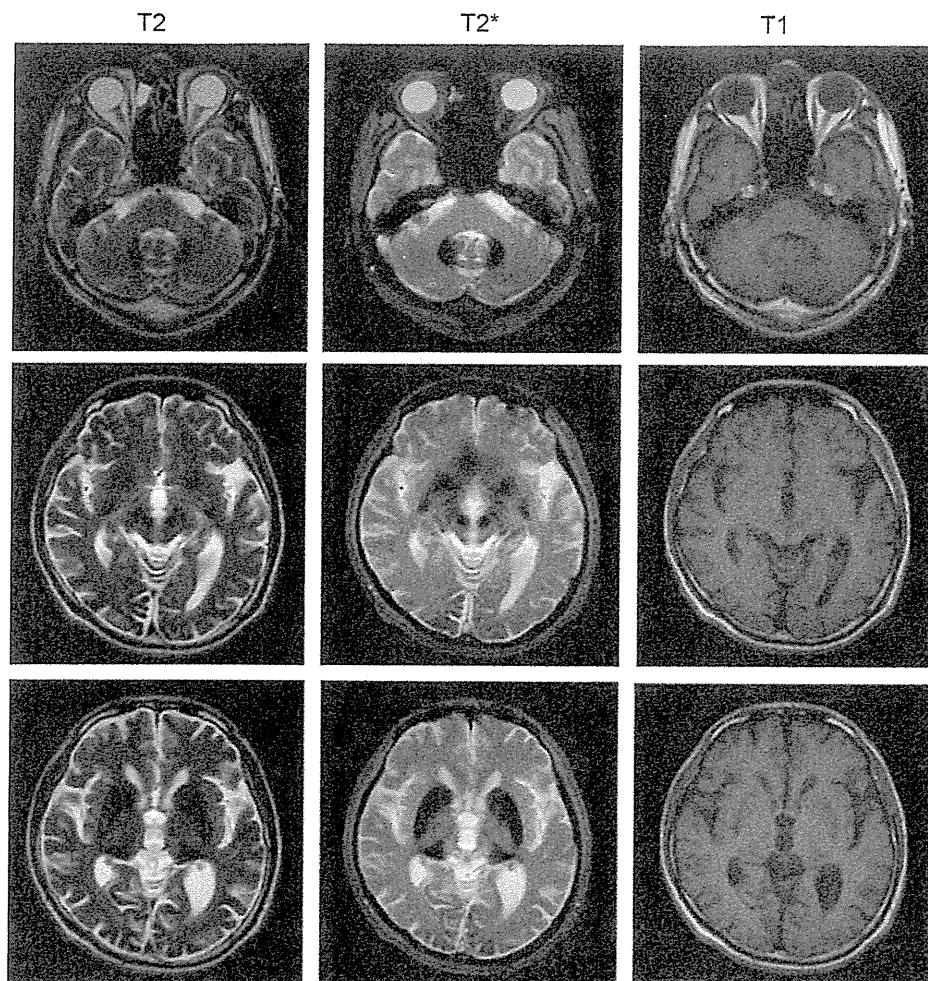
Magnetic resonance images (MRI) of an aceruloplasminemia patient. T1, T2 and T2*-weighted axial images of the brain showed signal attenuation of the dentate nucleus of the cerebellum, globus pallidum, putamen, caudate nucleus, and thalamus.
